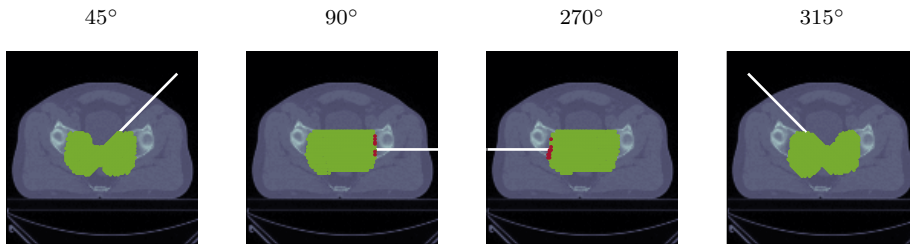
Axial CT slice for the prostate patient with different beam angles. The overlay highlights the spots in green (●) with sufficiently large residual helium range and the ones with insufficient residual helium range in red (●).
